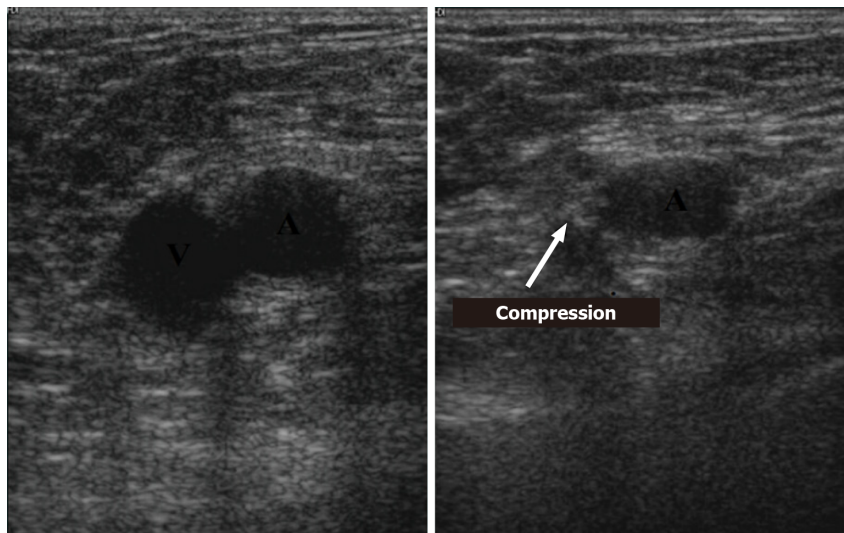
Compression ultrasound example.
